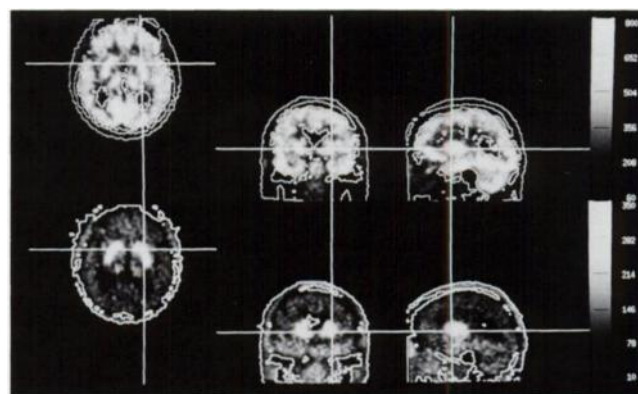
Coregistration of FDG-PET with F-Dopa-PET. Although F-Dopa images show preferential uptake in the basal ganglia, appropriate thresholds yield contours sufficiently well identified to achieve reliable coregistration. This is verified by superposition of the exchanged contours.
